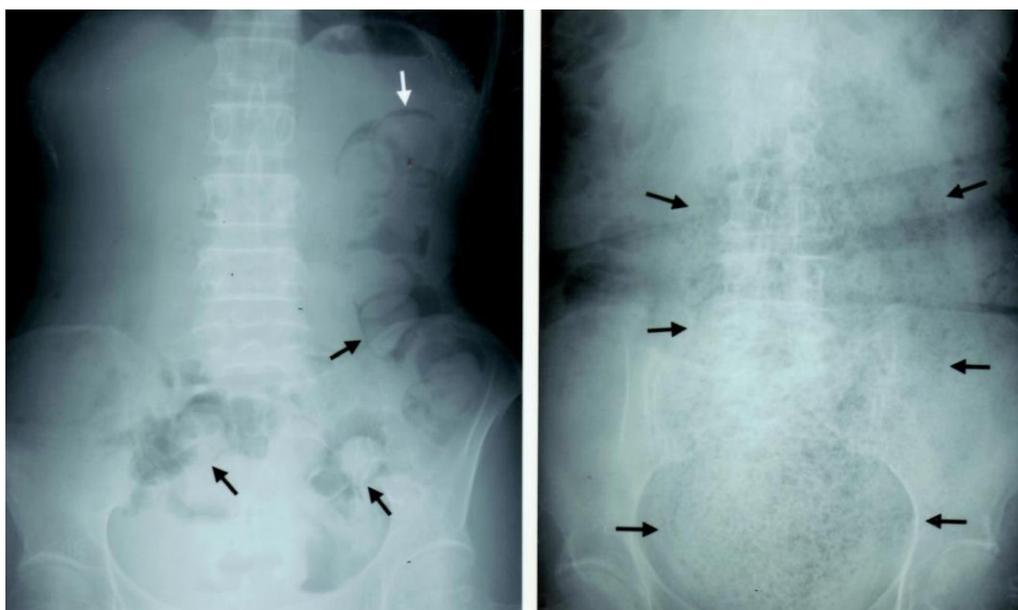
Fecal impaction in case 9 (left) and megabowel in case 11 (right). The simple radiograph of the abdomen showed multiple large, round masses of stool in the sigmoid and descending colon indicated by arrows, namely fecal impaction (left). The simple radiograph of the abdomen showed a huge stool mass manifested as numerous fine gas pictures. The border of the stool mass is indicated by arrows measuring 15.0 cm of the bowel width, namely megarectum and megacolon, which were confirmed by computed tomography. This megabowel caused huge abdominal distension (right).
